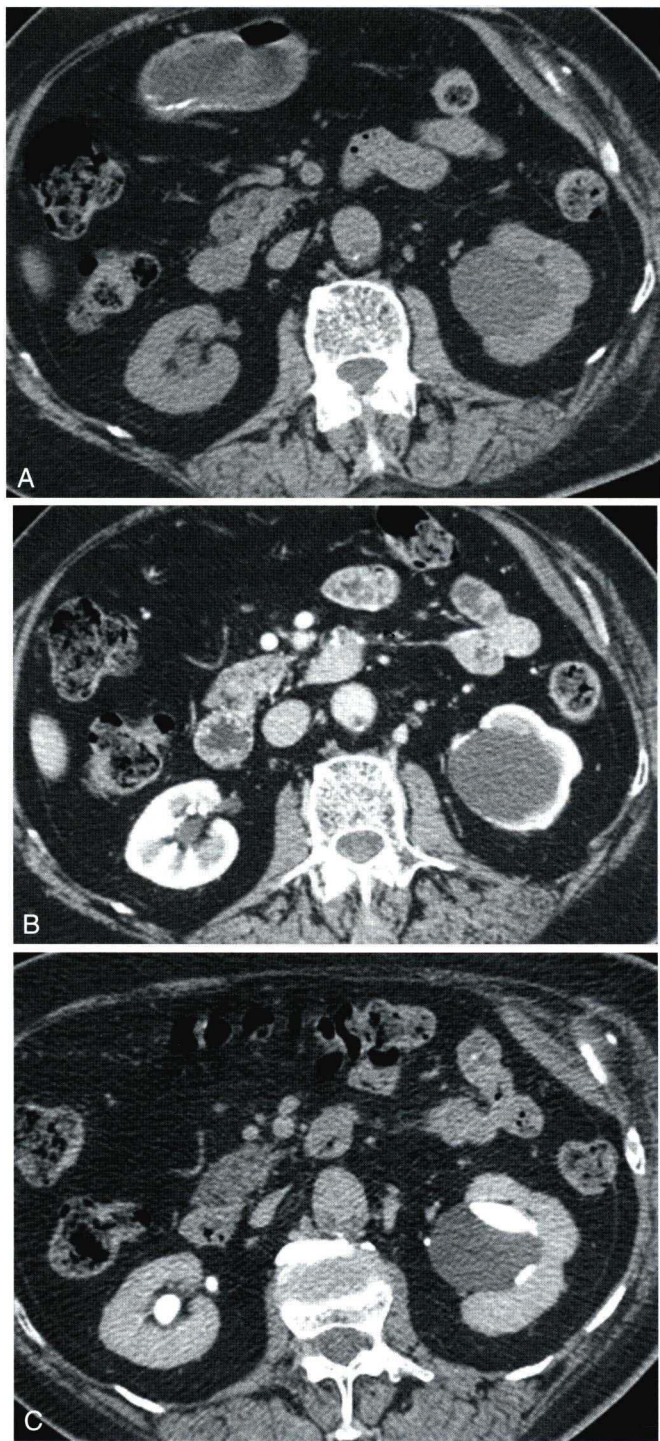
Computed tomography urogram (CTU) images show the three phases of a CTU. A, Noncontrast shows a cystic mass in the left renal sinus. B, Nephrogram phase is shown and is best for diagnosing renal tumors and urothelial tumors. C, Image shows the excretory phase and demonstrates that the cystic mass is a renal sinus cyst. Excretory phase is best for diagnosis of papillary necrosis and other abnormalities of the pyeloureteral lumen.
